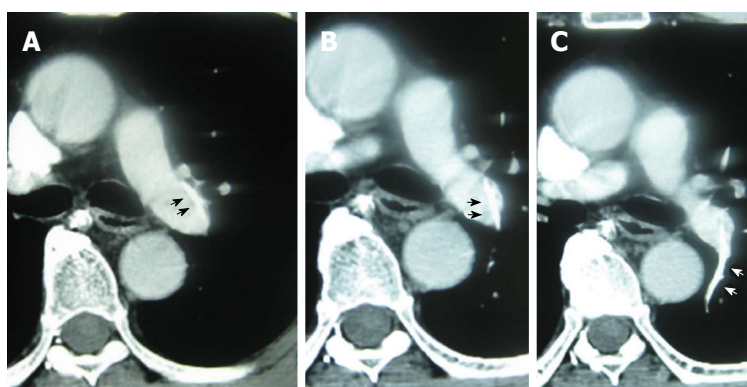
Contrast-enhanced computed tomography showing the proximal end of the catheter lodged in the wall of the left pulmonary artery trunk (A and B); the distal catheter end was in the small branch of left pulmonary artery (C). The broken catheter is indicated by arrows.
